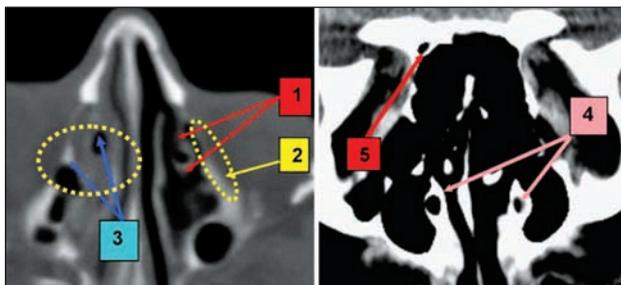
Paranasal sinuses CT scan: 1. pneumatized left uncinete process, adherent to the lamina papyracea; 2. lamina papyracea; 3. inflammatory process in the right anterior ethmoidal cells; 4. bilateral pneumatization of the uncinete process, verticalization; 5. pneumatization of the clinoid process
